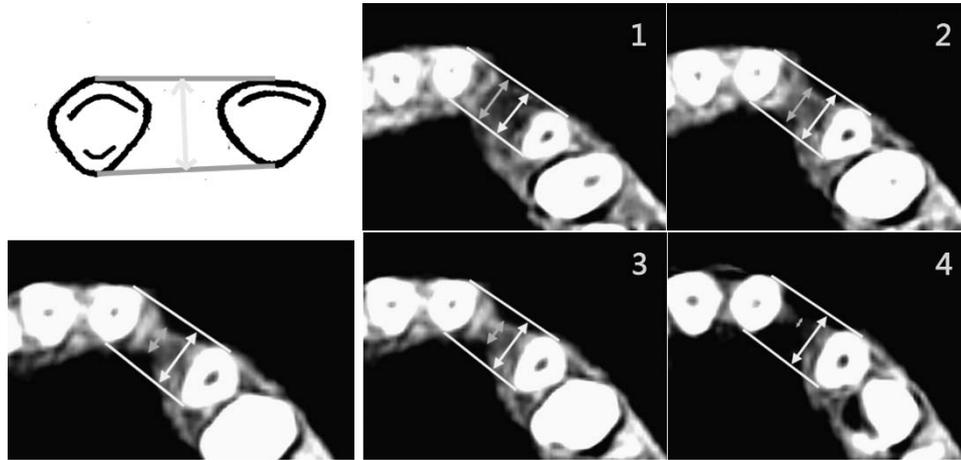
The grading scale used to assess the interdental bone thickness on cone beam computed tomography (compared with the root width of the cleft-adjacent teeth). DICOM images were displayed with window level of 1150 Hu and window width of 2000 Hu. Score 1 = the labiolingual thickness of the bony bridge is at least equal to the root width of the teeth adjacent to the cleft ($\geq 100\%$). Score 2 = the thickness of the bony bridge is at least three-quarters as great as the root width of the cleft-adjacent teeth ($\geq 75\%$). Score 3 = the thickness of the bony bridge is at least half as great as the root width of the cleft-adjacent teeth ($\geq 50\%$). Score 4 = the thickness of the bony bridge is less than half the root width of the cleft-adjacent teeth ($< 50\%$).
